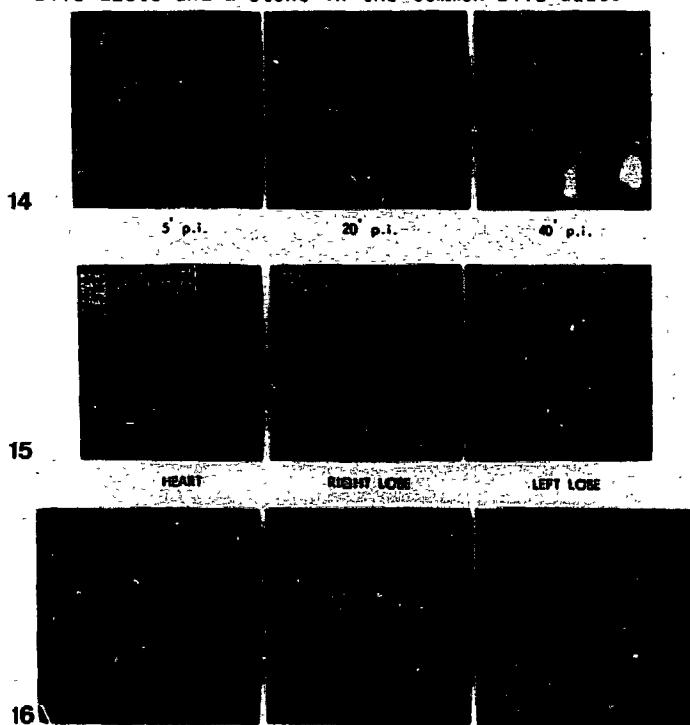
14-16 Cholescintigraphy in a patient with a stone in the common bile duct.
